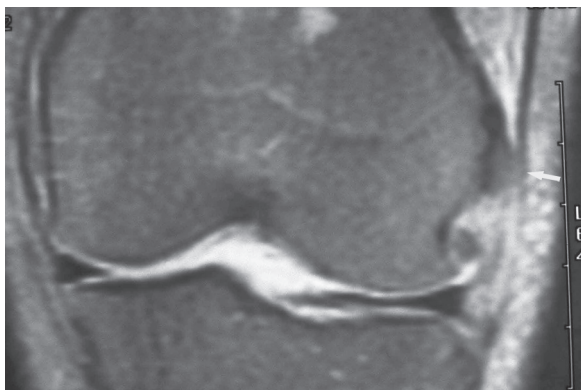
Coronal FSE PDW Fat Sat MRI. Iliotibial friction band syndrome in a female surfer. Note the bone exostosis of the lateral femoral condyle (arrow), which leads to an impingement on the iliotibial tract
